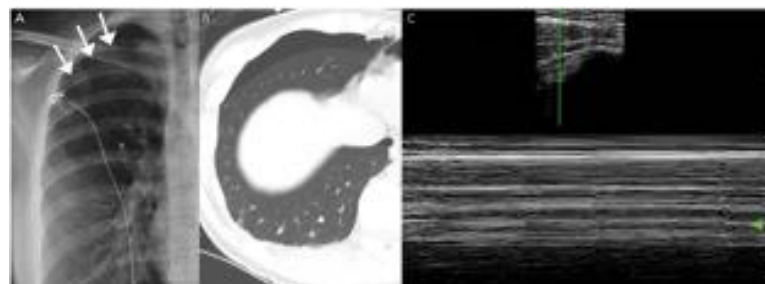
Pneumothorax on ultrasound of the lungs
